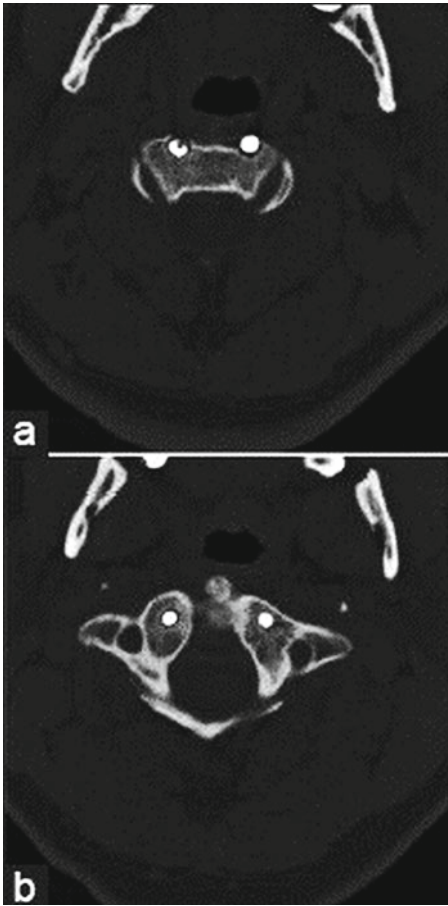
(a) Postoperative axial computed tomography (CT) demonstrating anterior atlantoaxial screw position in the axis. (b) Postoperative axial CT showing tip of screw in atlas
